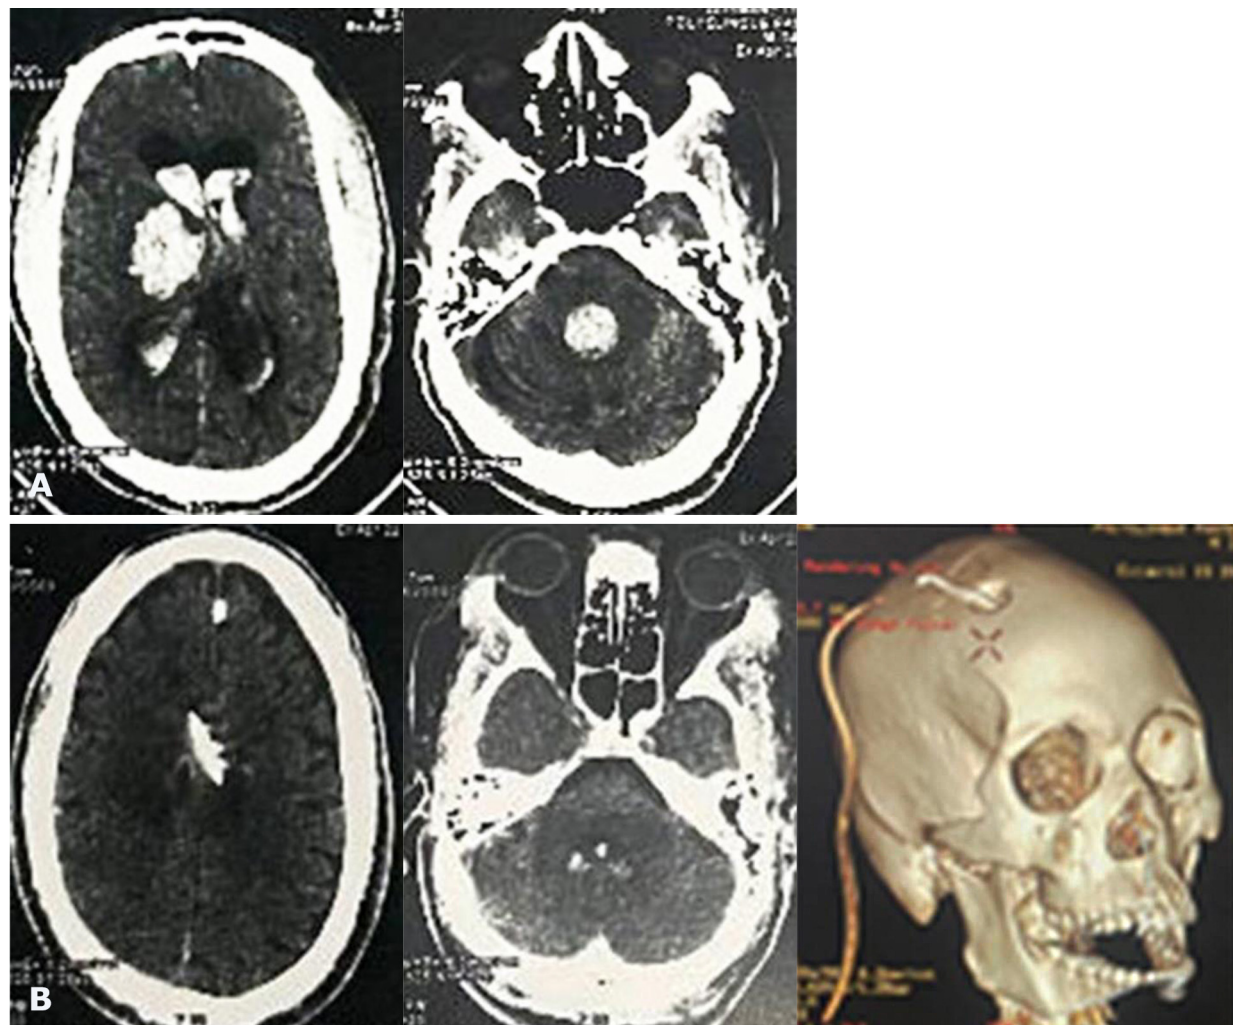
Preoperative CT scan showing ICH with IVH (A), and postoperative CT scan showing intraventricular catheter tip in the ventricle as well as the decrease of ventricle size and hematoma (B)
